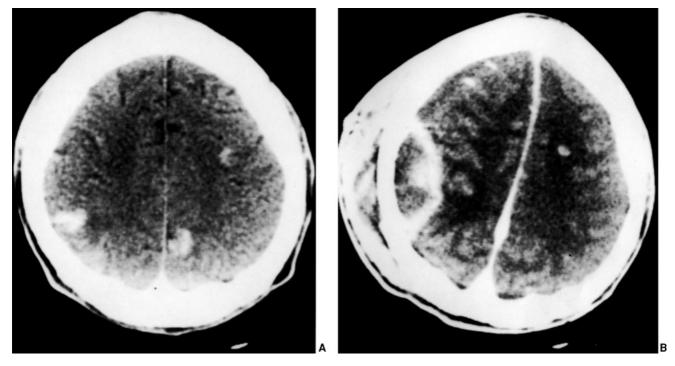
Bacterial infection (brain abscess): CT with contrast showing enhancing lesion near craniotomy defect after a biopsy for suspected toxoplasmosis.
